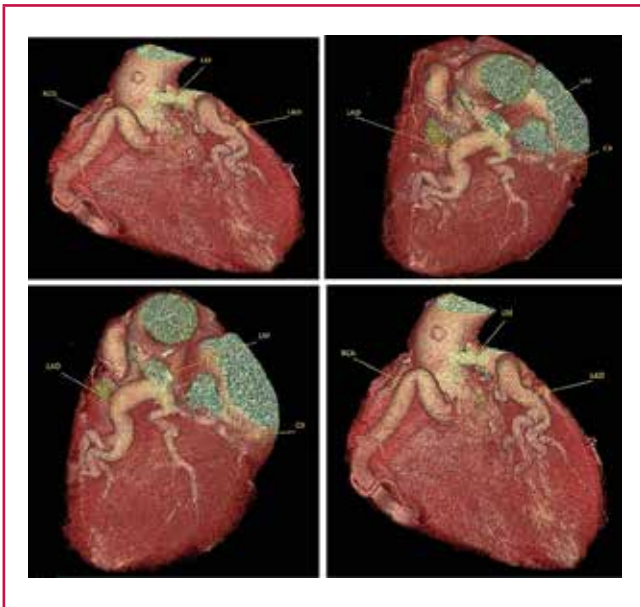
Postoperative computed tomography imaging.
